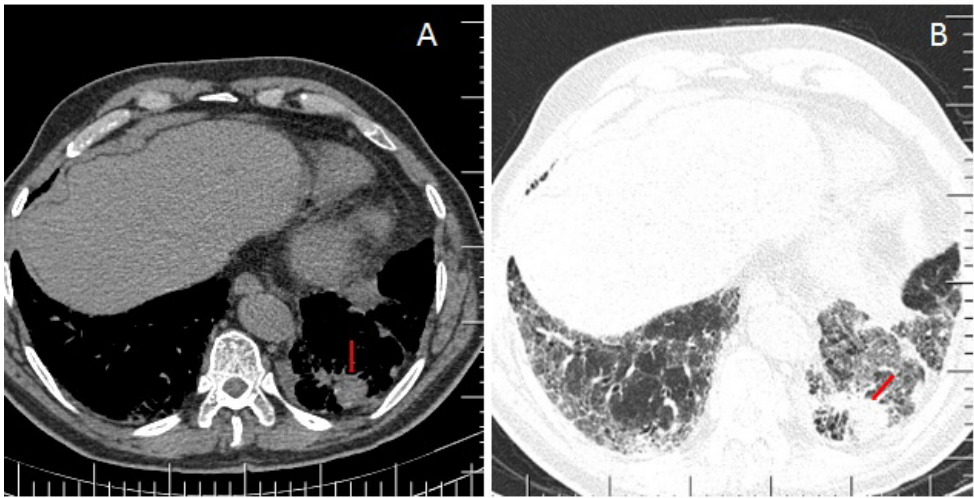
A 64-year-old man with interstitial pulmonary fibrosis and pathologically confirmed diagnosis of lung adeno cancer. A-B: Axial high resolution CT image obtained at the level of the lung base shows ground glass opacity and reticular densities. Axial high resolution CT and mediastinal window image show a mass with soft tissue density at the periphery of the left lower lobe (open arrow).
